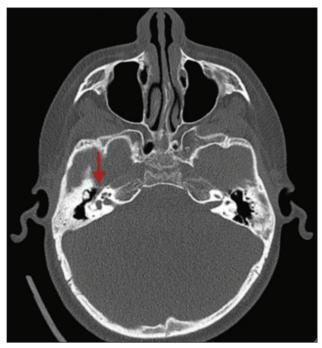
CT* of a patient who presented with a right LMN facial nerve palsy showing a cholesteatoma with a dehiscent facial nerve bony canal (arrow).
